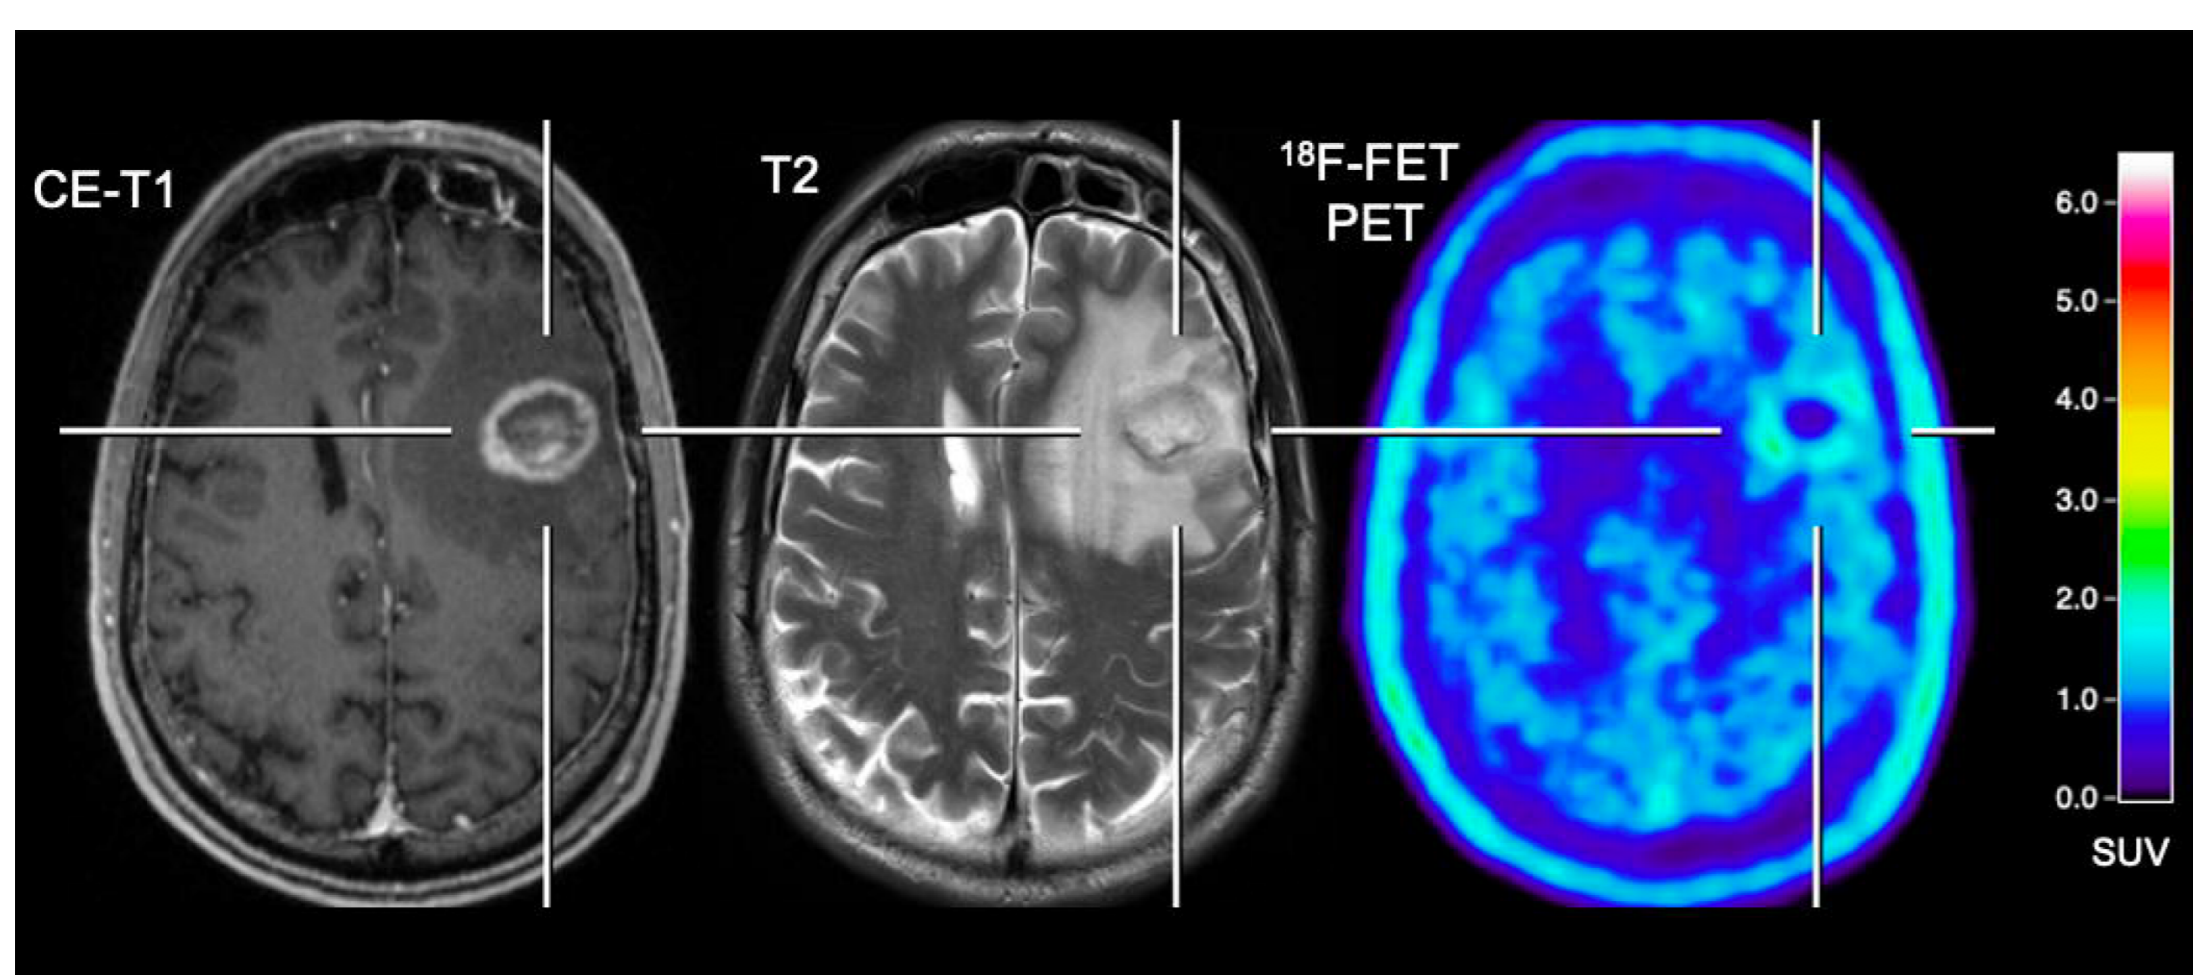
Patient with a melanoma brain metastasis pretreated with radiosurgery, dabrafenib+trametinib, and nivolumab. In contrast to the progressive MRI, amino acid PET using FET shows no significant uptake and is consistent with treatment-related changes
